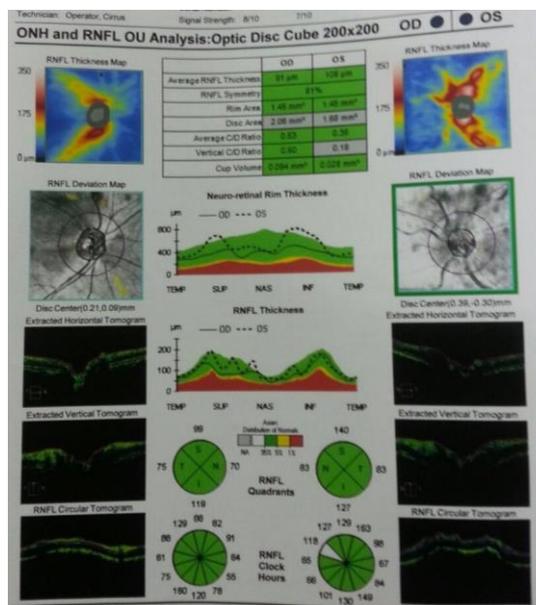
Ocular computed tomography (OCT) revealed normal disc on right eye and swelling disc on the left eye
